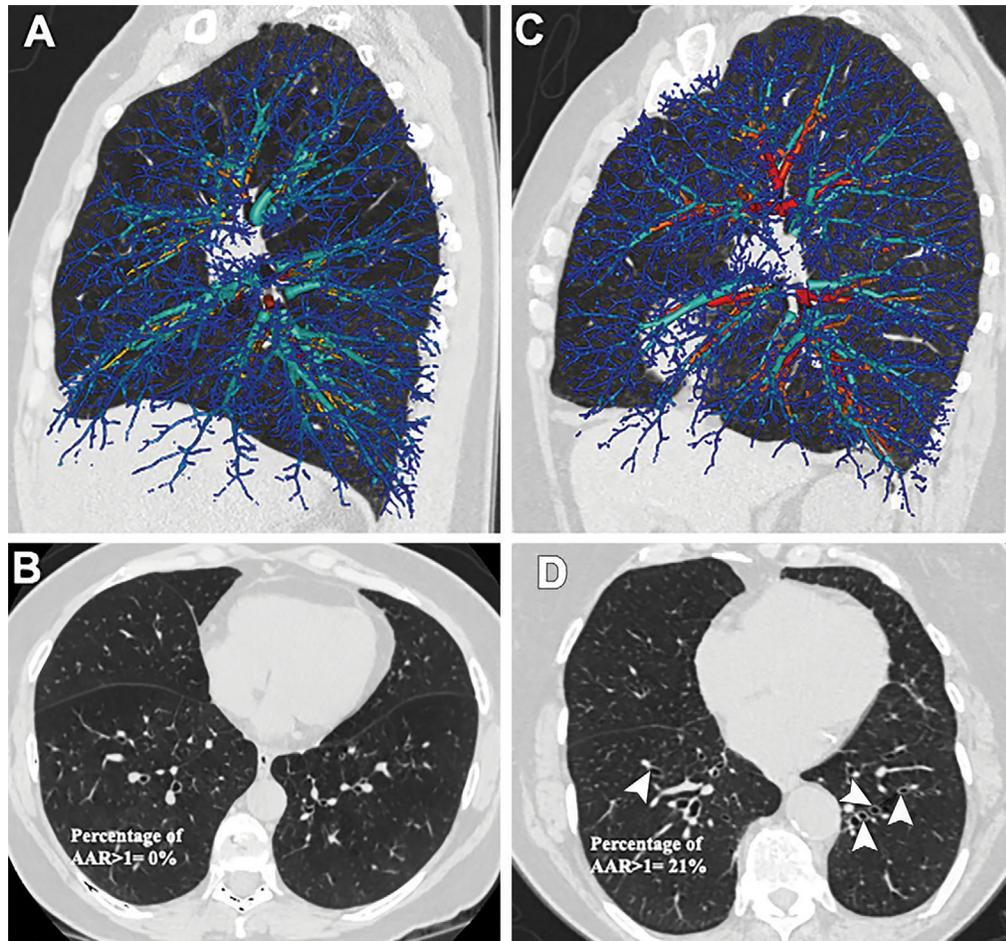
Three-dimensional CT reconstructions of the pulmonary arterial and bronchial trees. (A, C) The pulmonary arterial tree is color-coded, with cyan and blue indicating large and small branches, respectively, and the bronchial tree is color-coded, with red and orange indicating large and small branches, respectively. (A, B) Images in a 66-year-old woman with chronic obstructive pulmonary disease (COPD) without bronchiectasis. (C, D) Images in an 80-year-old woman with COPD with bronchiectasis (arrowheads in D). (B, D) Images show the percentage of artificial intelligence–based airway-to-artery diameter ratios (AARs) greater than 1.
